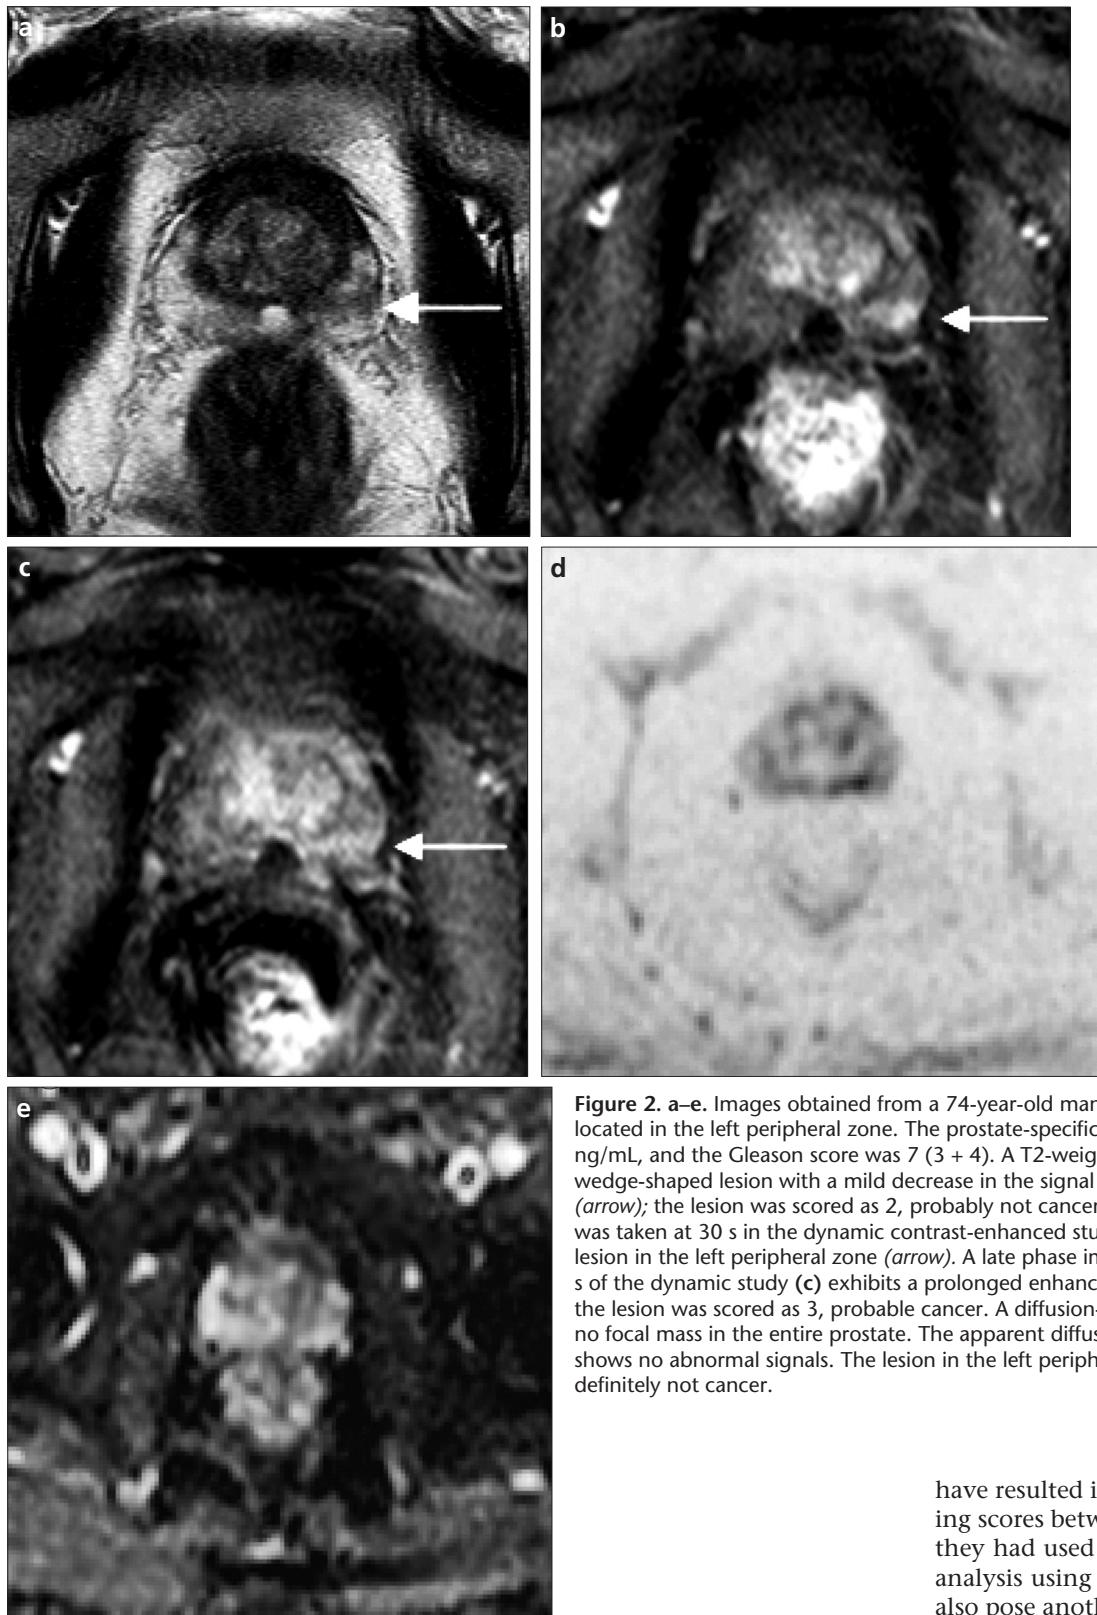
a-e. Images obtained from a 74-year-old man with prostate cancer located in the left peripheral zone. The prostate-specific antigen level was 5.79 ng/mL, and the Gleason score was 7 (3 + 4). A T2-weighted MR image (a) shows a wedge-shaped lesion with a mild decrease in the signal in the left peripheral zone (arrow); the lesion was scored as 2, probably not cancer. An early phase image that was taken at 30 s in the dynamic contrast-enhanced study (b) shows an enhanced lesion in the left peripheral zone (arrow). A late phase image that was taken at 180 s of the dynamic study (c) exhibits a prolonged enhancement of the lesion (arrow); the lesion was scored as 3, probable cancer. A diffusion-weighted image (d) shows no focal mass in the entire prostate. The apparent diffusion coefficient map (e) shows no abnormal signals. The lesion in the left peripheral zone was scored as 1, definitely not cancer.
